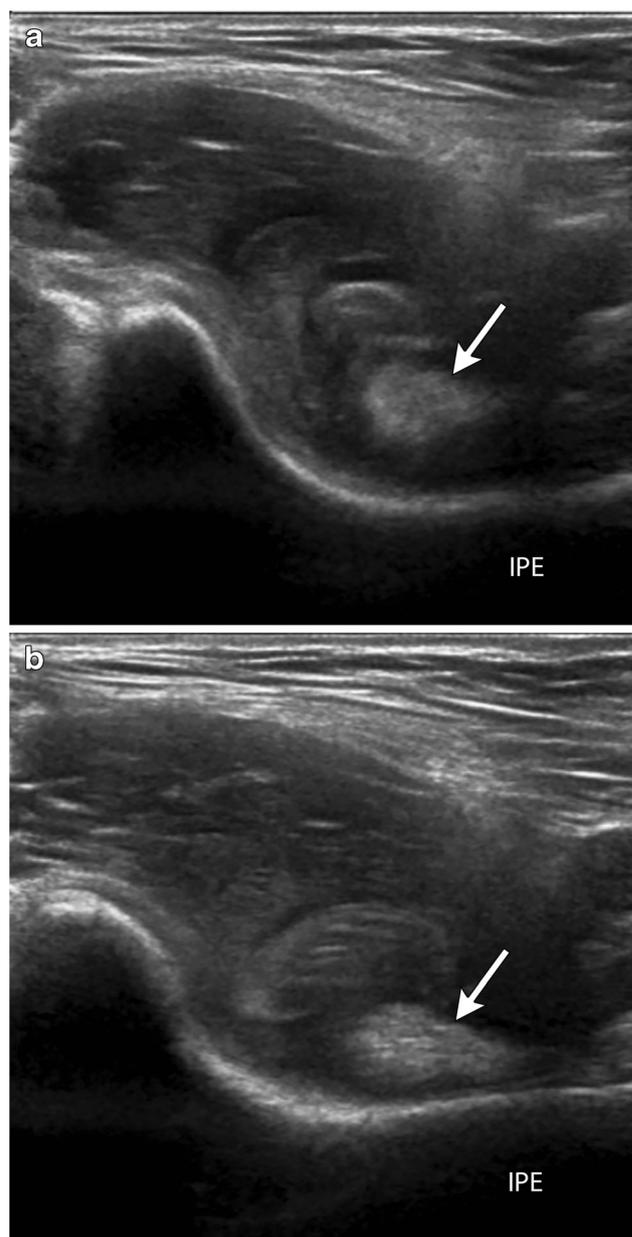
A 14-year-old dancer with snapping hip syndrome. Transverse grayscale ultrasound images show abrupt motion of the iliopsoas tendon (arrows) as the hip is moved between flexion/abduction (a) and extension (b). IPE = iliopectineal eminence
